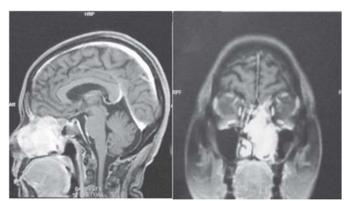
Sagittal and coronal MRI showing an enhancing left nasal cavity mass extending to the left anterior cranial fossa in this case of a patient with Cushing's syndrome secondary to esthesioneuroblastoma.
